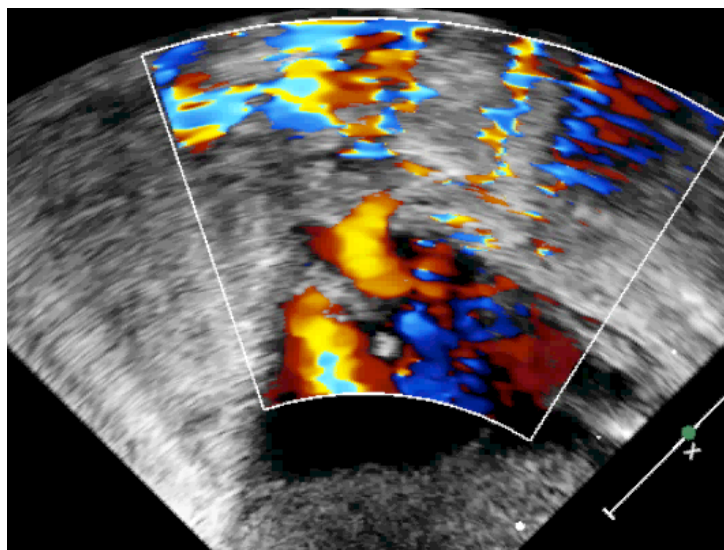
Two-dimensional transthoracic echocardiographic image with color Doppler from a subcostal coronal view A Christmas tree appearance to the confluence, with upper veins (UV) and B lower veins (LV) entering at different levels.
